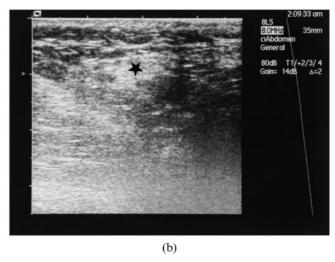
Spermatic cord complications. A 58-year-old man with inguinal hernia repair performed 30 days before, and a mass in the right inguinal canal. (a) The ultrasound performed showed a thicken spermatic cord (head arrows). (b) 1 year later the spermatic cord presents a normal size (*).
